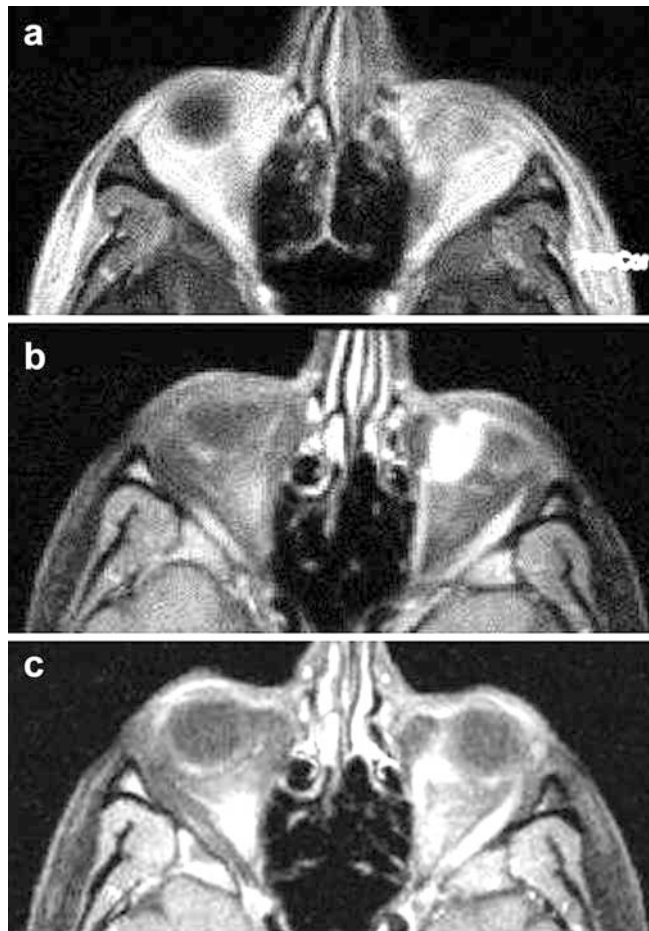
Patient 1. a T1-weighted cranial MRI with bulb asymmetry. b T1-weighted, contrast-enhanced MRI with fat suppression: clearly visible tumor inferior of the left bulbus. c MRI 3 months after initiation of therapy (T1-weighted, contrast-enhanced MRI with fat suppression)
